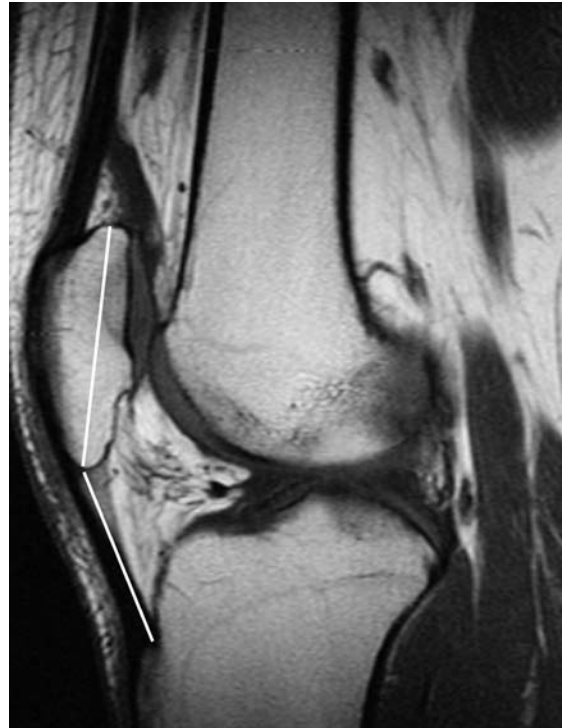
Patella baja of the right knee in a 37-year-old woman. Sagittal SETI-W MR image of the right knee shows an Insall and Salvati index of 0.74.
